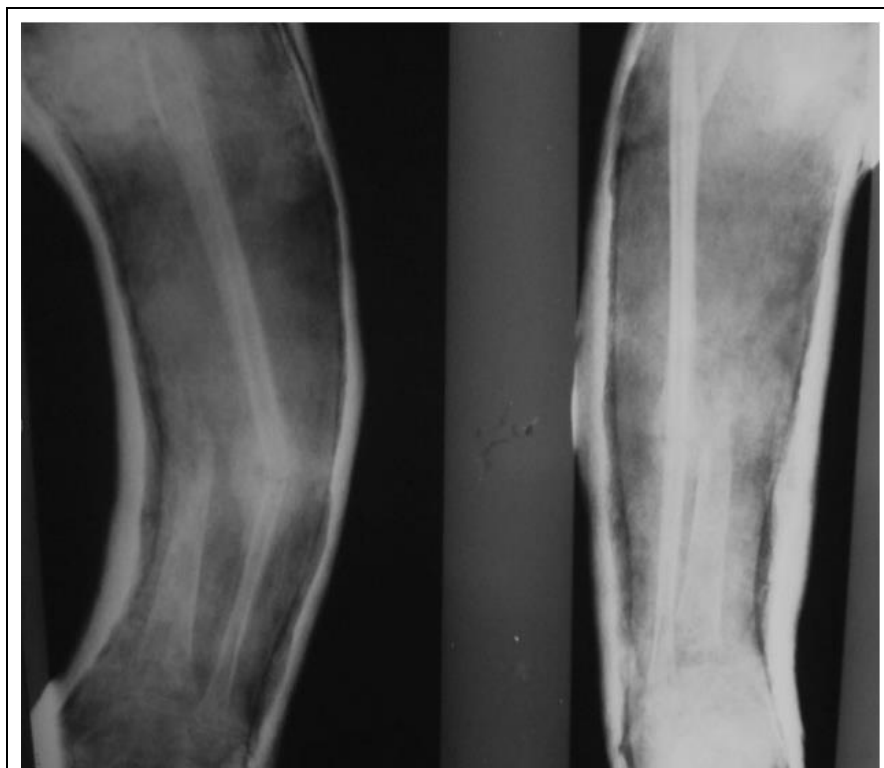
X-ray right tibia AP and lateral after elimination of infection.
